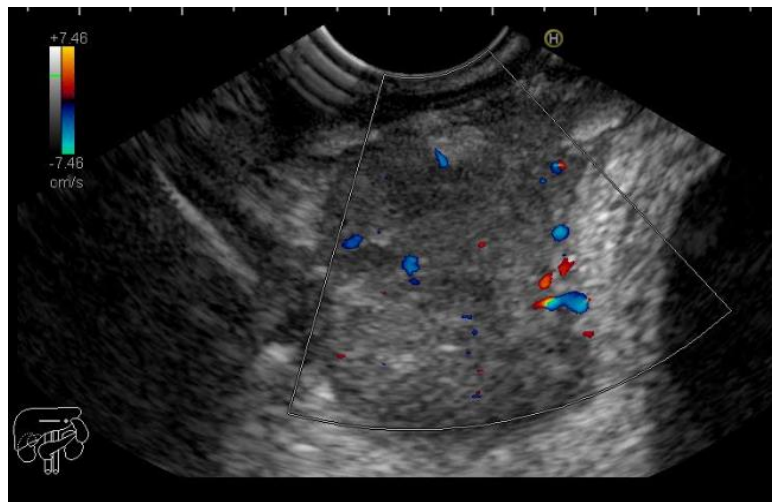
EUS showed a well-defined heterogeneous slightly echogenic solid mass with central calcifications and no significant flow on color Doppler
